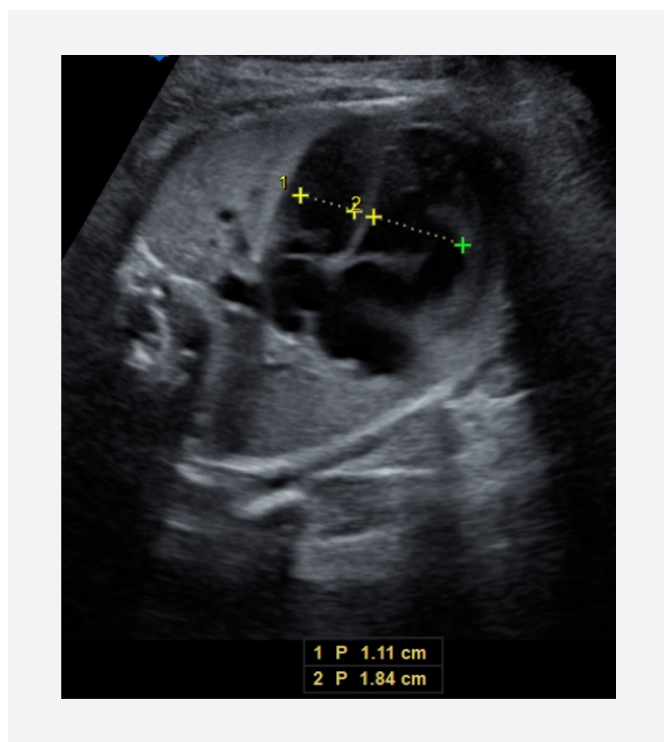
Ultrasonography of the fetal heart at 20 weeks' gestation (verified diagnosis). Anomalous 4-chamber view, measurement of the ventricular cavity width, decrease in the left ventricle size (indirect sign of an aortic pathology)
